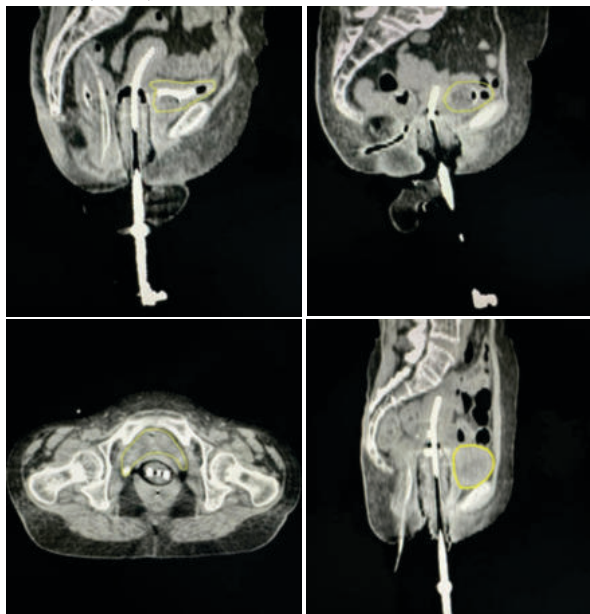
shows brachytherapy contouring and planning CT images representing various bladder morphologies, namely flat, ellipsoid, horseshoe, and globular, respectively. The bladder is represented by a yellow contour. Image that requires colour in print
